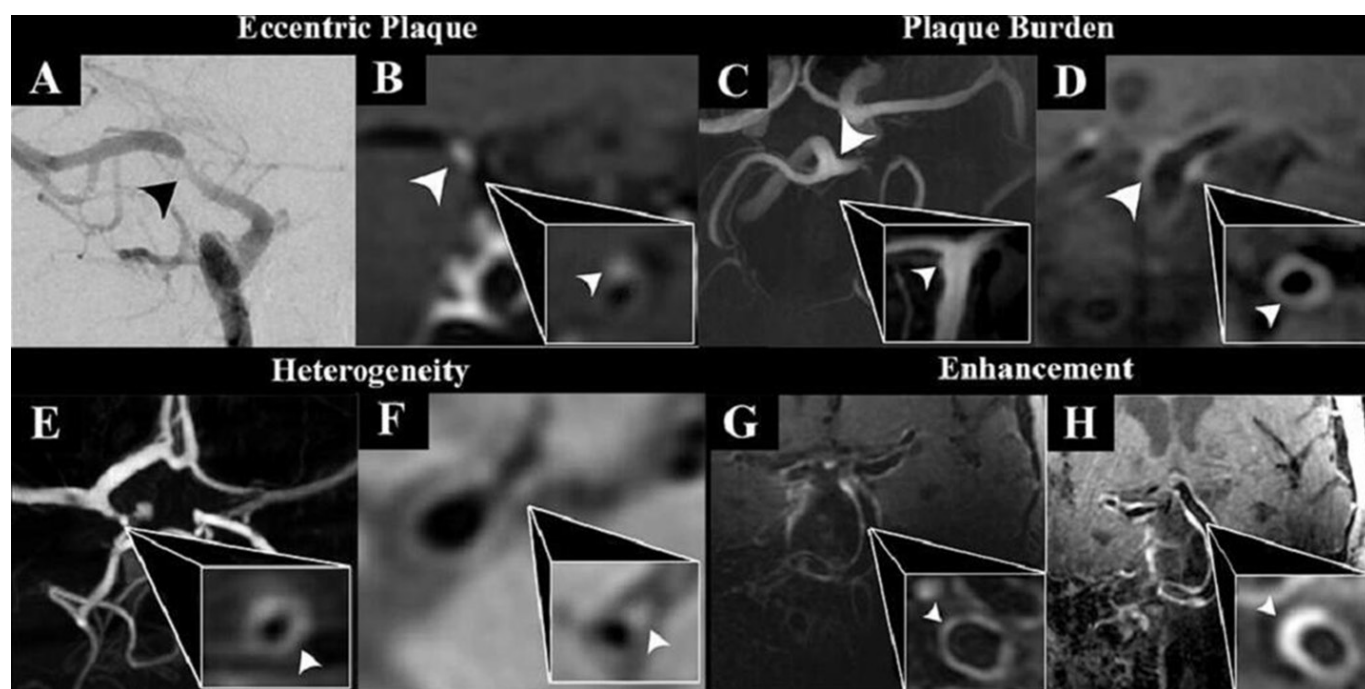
Characteristics of intracranial atherosclerotic plaques. Based on WASID criteria, the degree of stenosis caused by an atherosclerotic plaque is an important risk factor for stroke; however, other morphological characteristics of the plaque are also very relevant. (1) Eccentric versus concentric plaques. (A) This digital subtraction angiogram (DSA) shows a plaque (arrowhead) causing significant stenosis in the distal internal carotid artery (ICA). (B) A 7T high-resolution MRI (HR-MRI) shows the presence of an enhancing and eccentric plaque (arrowhead), suggesting that the most likely etiology of this stenosis is intracranial atherosclerosis. (2) Plaque burden. (C) In this case, magnetic resonance angiography (MRA) of a patient with cryptogenic stroke in the posterior circulation shows a small irregularity in the basilar artery (inset, arrowhead). (D) A 7T HR-MRI shows a circumferential plaque with significant plaque burden, despite no evident luminal stenosis (arrowhead) on MRA. (3) Heterogeneity. (E) The heterogeneity of the signal intensity within the plaque is possibly associated with intraplaque hemorrhage (IPH), the presence of calcification, or a lipid core. A 7T HR-MRI enables visualization of a heterogeneously enhancing plaque (arrowhead). (F) Moreover, hyperintense areas in T1-weighted images are suggestive of regions of angiogenesis and IPH within the plaque (arrowhead). (4) Enhancement. (G) A basilar artery plaque in a patient with recurrent transient ischemic attacks (arrowhead). (H) The patient did not start maximal medical therapy and the levels of low-density lipoprotein and HbA1c increased over time. Follow-up imaging showed increased plaque enhancement (arrowhead).
